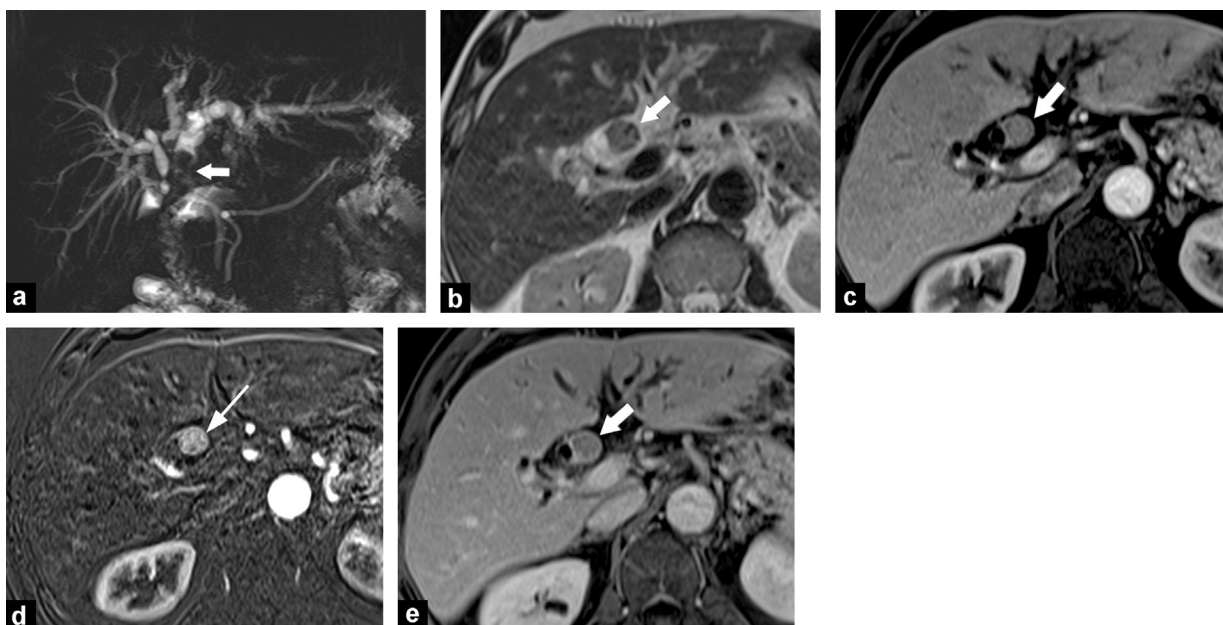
Preoperative MR imaging of the liver and biliary tract in a 63-year-old man with endobiliary hepatocellular carcinoma: a: MR cholangiography image in the coronal plane shows markedly hypointense endobiliary tumor (arrow) located at the biliary confluence; b: on T2-weighted fast spin echo MR image in the transverse plane, the tumor (arrow) is isointense relative to the hepatic parenchyma; c: on T1-weighted MR image obtained during the arterial phase after IV administration of a gadolinium chelate, the tumor (arrow) shows enhancement similar to that of hepatic parenchyma; d: endobiliary tumor enhancement (arrow) is more visible on subtracted image; e: delayed phase image shows subtle washout. No biliary wall thickening or sign of peribiliary invasion is visible on any sequence.
